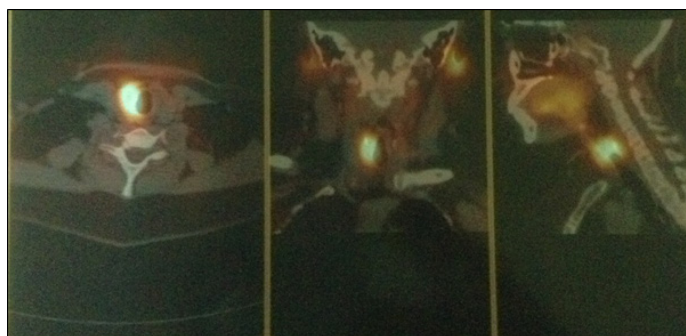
Parathyroid SPECT/CT show adenoma of the lower right parathyroid gland
